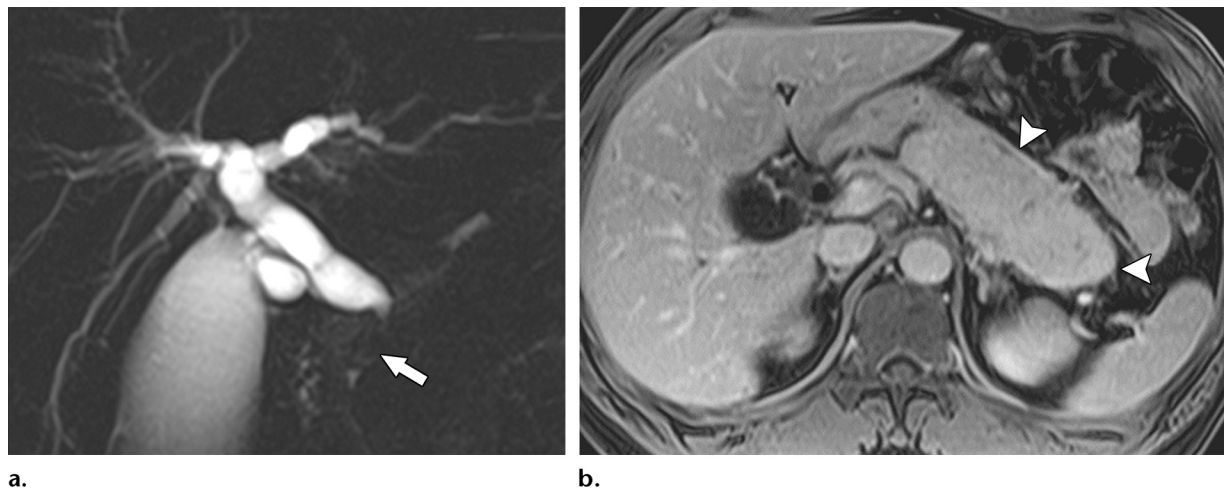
Simultaneous occurrence of IgG4-related sclerosing cholangitis and type 1 autoimmune pancreatitis in a 42-year-old man. (a) Coronal T2-weighted MR cholangiopancreatographic image shows short-segment stricture (arrow) of the distal common bile duct, with upstream biliary ductal dilatation. (b) Axial contrast-enhanced T1-weighted MR image (portal venous phase) obtained after administration of gadolinium-based contrast material shows a sausage-shaped pancreas with an enhancing peripancreatic soft-tissue rim (arrowheads), findings consistent with type 1 autoimmune pancreatitis.
